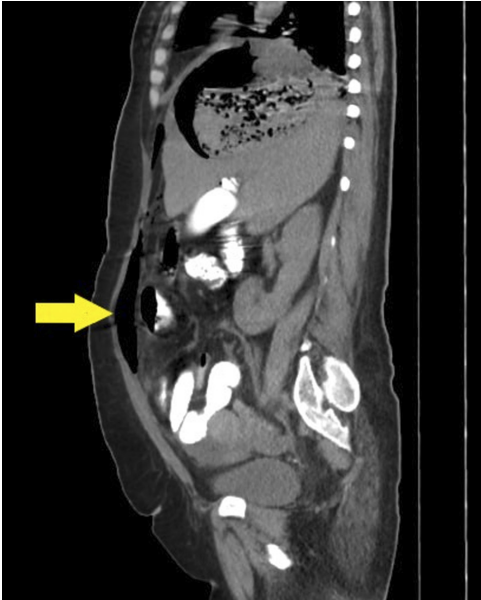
Preoperative computed tomography image of ruptured liver hydatid cyst: yellow arrow shows intraperitoneal free air due to perforation (sagittal image).
